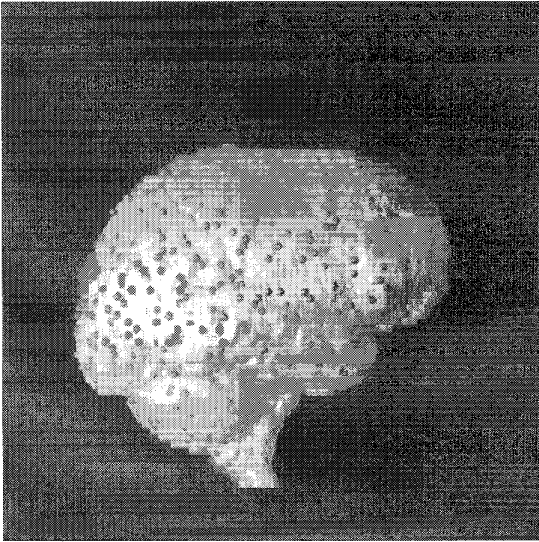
Example of registering MRI data sets from different times. A subsample set of surface points from one image are matched and overlaid on the surface of the second image.
